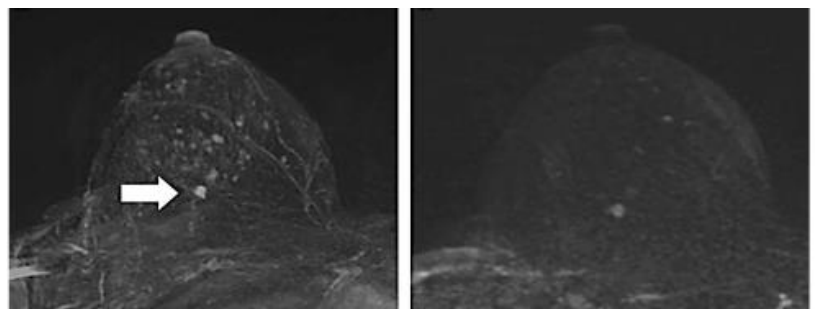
A typical finding of breast cancer (arrow) detected on MRI [21]
